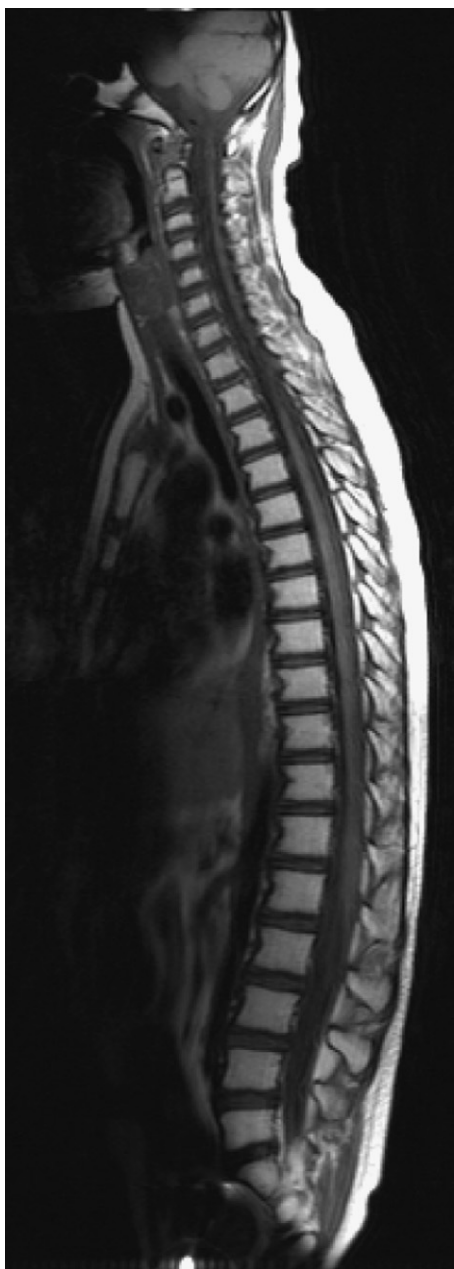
Sagittal gadolinium-enhanced T1-weighted MRI reveals no spinal lesions before the cranial irradiation.
